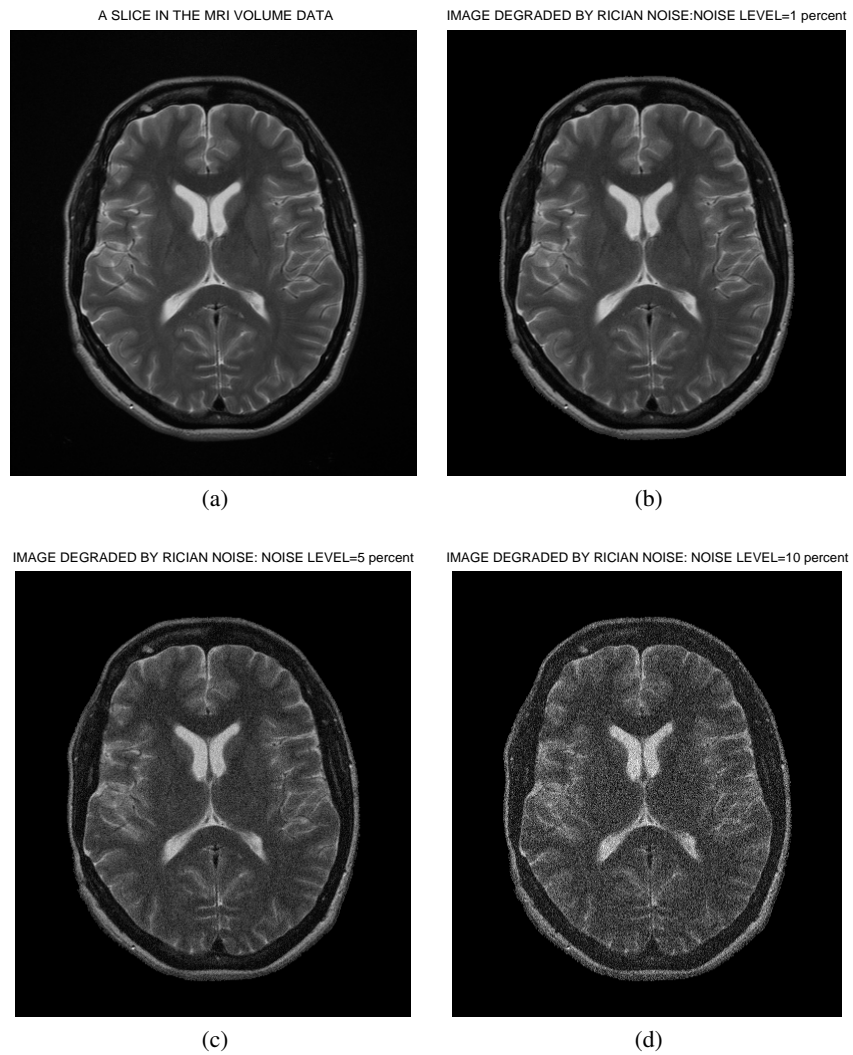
A slice in the MRI volume data without noise degradation (a). The same slice in (a) with different levels of noise degradation, (b) noise level =1 percent, (c), noise level=5 percent and (d) noise level=10 percent.
